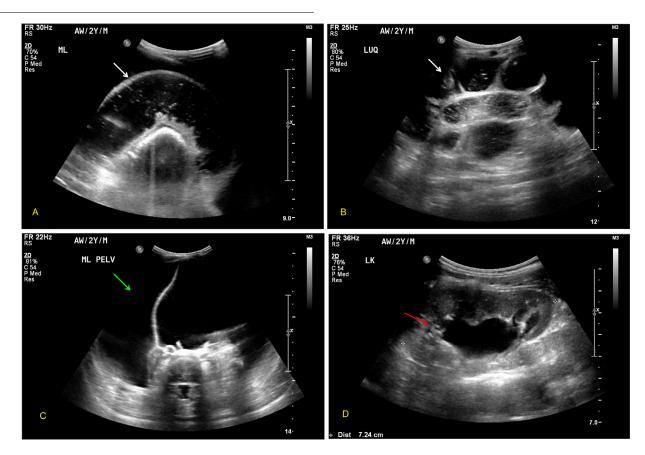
Abdominal ultrasound. (A, B) Dilated owl segments at midline and LUQ (white arrows). (C) Large cystic lesion occupying the pelvis with separation and floating debris (green arrow). (D) Left kidney with dilated renal pelvis (red arrow); hydronephrosis were noted bilaterally.
